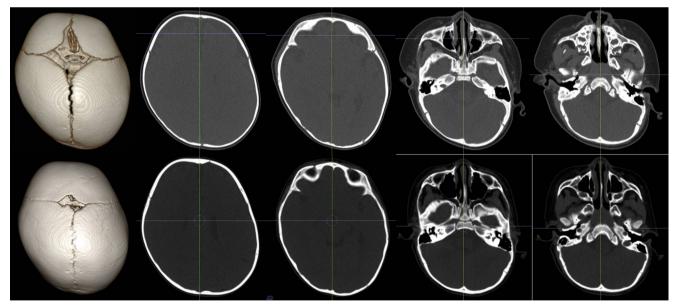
Computed tomography images of an 8-month-old male infant with right-sided plagiocephaly. *Upper row* before treatment; *lower row* after treatment. From *left* to *right*: 3D CT image above vertex, upper cranial level, lower cranial level, midface level, and ear tragus level. 3D CT image was flipped as a mirror image to make it easy for understanding. Right occipital flattening, frontal bossing, and anterior displacement of right ear were noted before treatment. Significant
